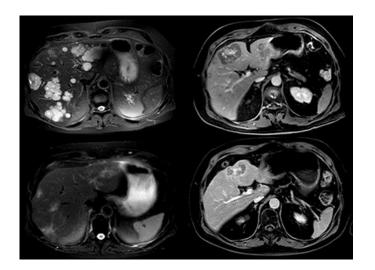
Fat-saturated T2-weighted (left column) and gadolinium-enhanced (right column) MR imaging before (upper row) and 6 weeks after radioembolization (bottom row). Prior to radioembolization, multiple, multifocal, centrally hypervascularized metastases were found in both liver lobes. On follow-up, tumor burden significantly diminished.
